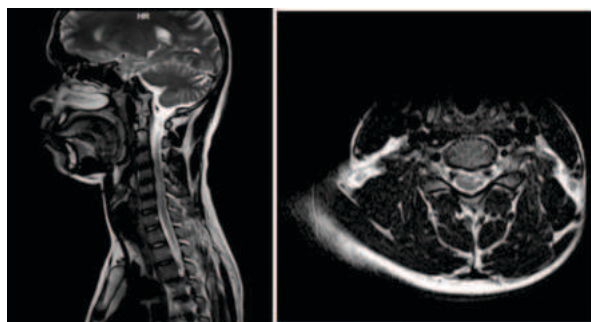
MRI CERVICAL SPINE- shows T2 hyperintensity involving the C4, C5, and C6 segments, particularly affecting the anterior horn cells on the left side
